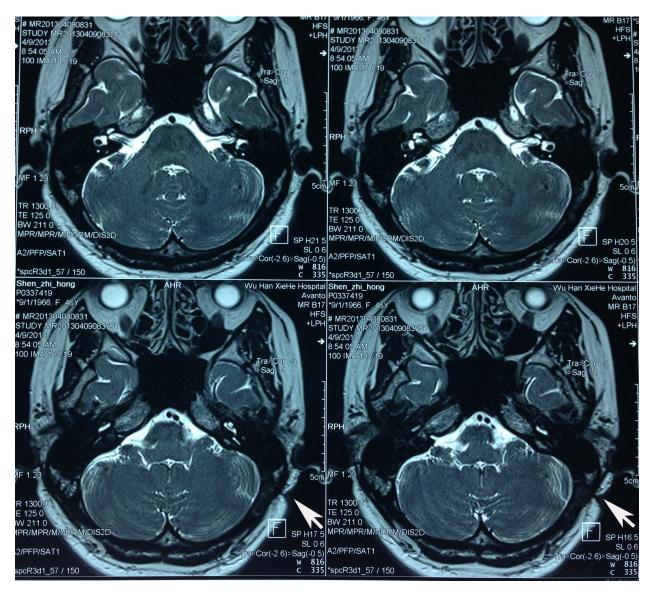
At 4 months after the operation and 1 month after the complete healing of the wound, a MRI (3D-CISS) scan was performed. The depression of the skin in the wound area can be seen (%); the dura mater is intact with the artificial dura mater closely attached to the patient's own dura mater and is very difficult to distinguish. There were no abscesses superficial to the dura mater.
